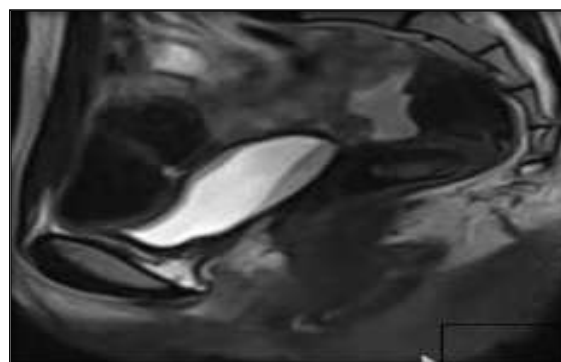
Sagittal T2 MRI showing lower 1/3 of vagina with absent uterus at uterine fossa.
